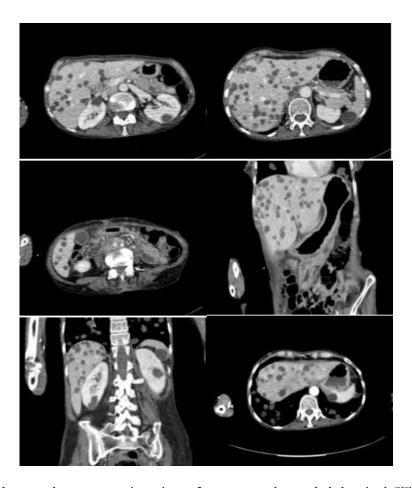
Axial and coronal reconstruction view of contrast-enhanced abdominal CT shows multiple cystic lesions in liver, both kidneys, pancreas and spleen
